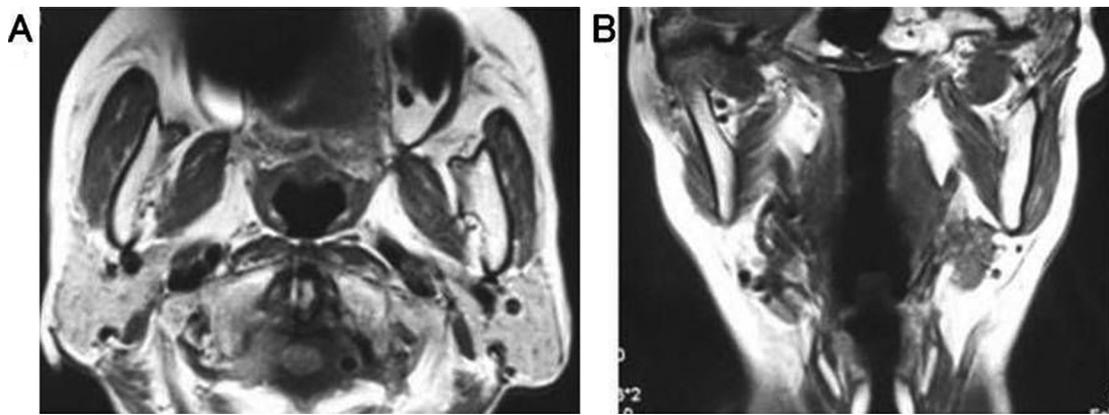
Magnetic resonance imaging at the first examination. A horizontal T1-weighted image is shown on the left and a frontal T1-weighted image on the right. No structural changes were detected in the parotid glands, masseter muscle, parapharyngeal space, or neck region, and there were no findings of a tumor or inflammation.
